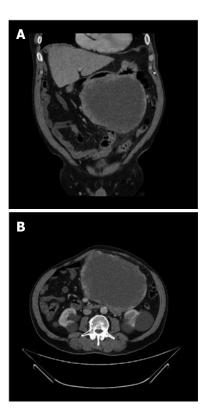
Preoperative computed tomography scan of the abdomen and pelvis showing a large mass inseparable from the greater curve of the stomach. A: Coronal view; B: Axial view.
